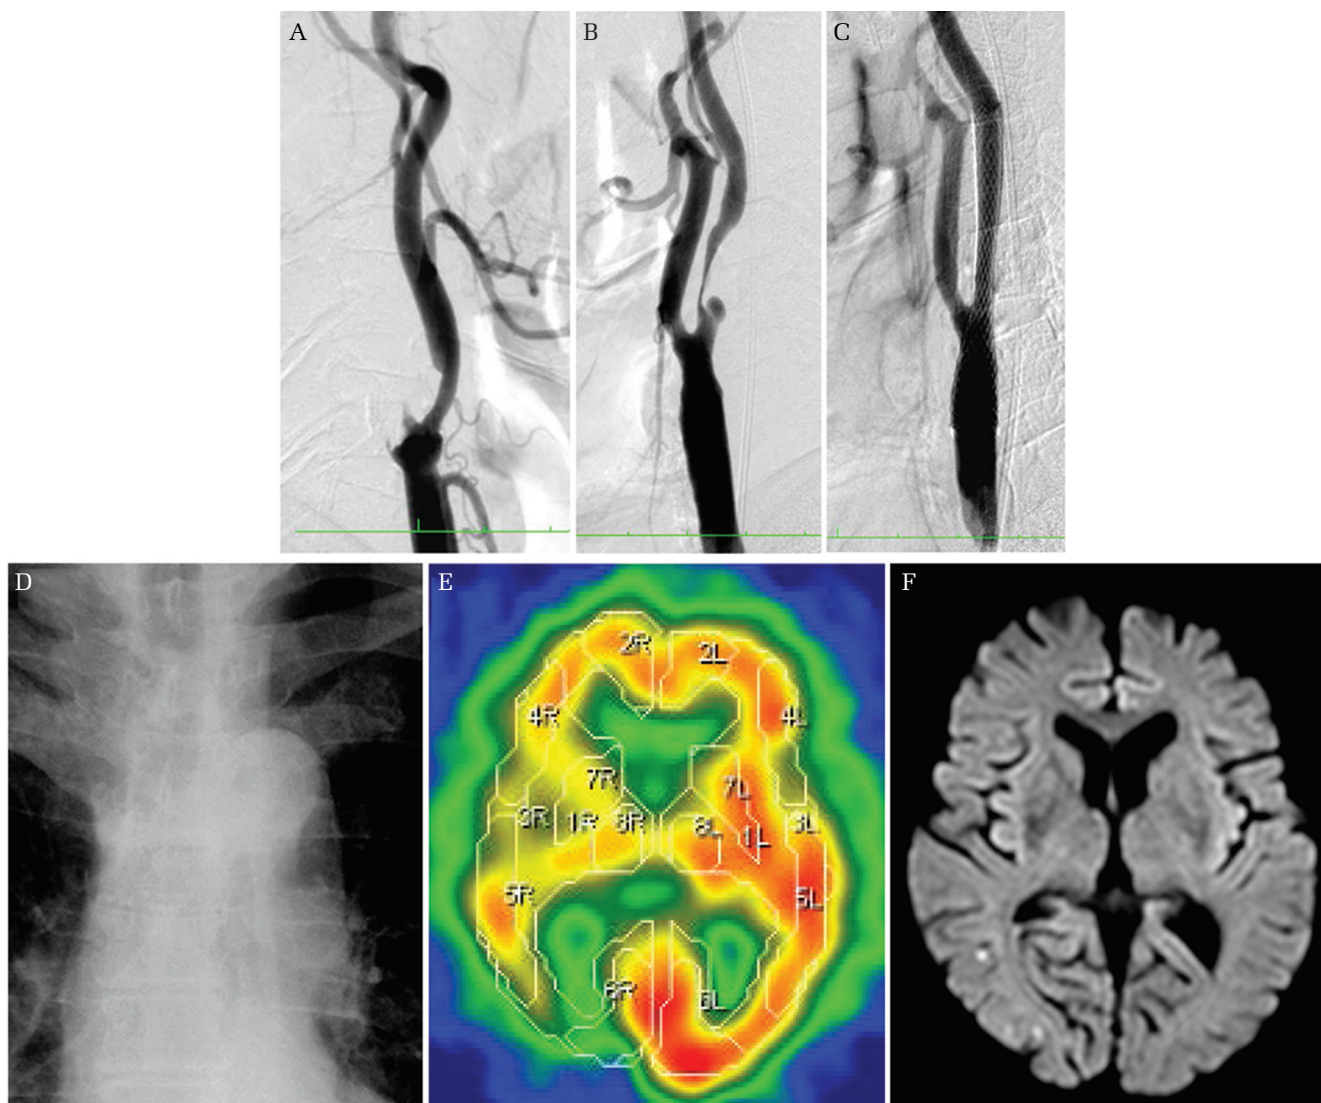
Left-sided CAS was performed in an asymptomatic 75-year-old man. (A and B) An angiogram showing (A) the right carotid artery completely occluded and (B) the left carotid artery with 93% stenosis before stenting. (C) An angiogram of the left carotid artery shows successful dilatation of the carotid lumen after stenting. (D) AAC on the chest X-ray indicated Shimada's grade 0. (E) Preprocedural single-photon emission computed tomography with I^{123} -labeled *N*-isopropyl-*p*-iodoamphetamine showed reduced cerebral blood flow on the right side. (F) Postprocedural diffusion-weighted magnetic resonance imaging showed multiple MIs only in the right cerebral hemisphere.
